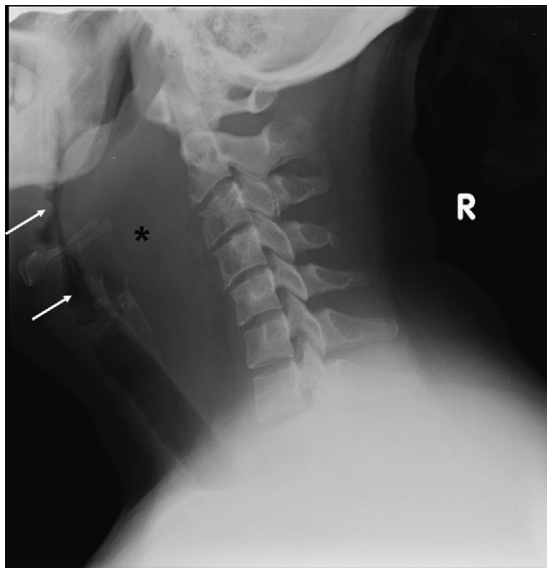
Plain lateral radiograph of the neck in soft tissue window shows a large retropharyngeal soft tissue mass (asterisk) causing narrowing and anterior displacement of the trachea (white arrows). There was anterior scalloping of the cervical vertebral bodies.
